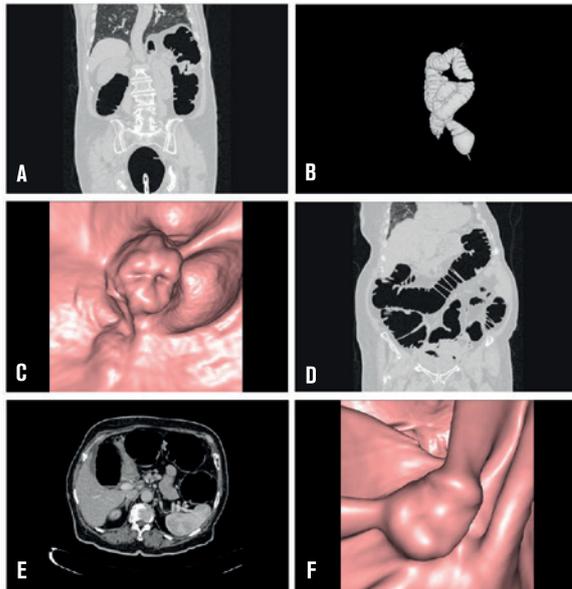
A 79 year-old female patient who had severe abdominal pain and constipation has undergone conventional colonoscopy but splenic flexure could not be passed because of obstructive tumor; coronal MPR (A), CT colonographic (B), 3D endoluminal (C) images demonstrating tumoral wall thickening at proximal descending colon leading to annular narrowing of the lumen; coronal MPR (D), axial (E), 3D endoluminal (F) images demonstrating broad-based synchronous polypoid lesion in dimension of 1x2 cm at distal transverse colon. The pathology report of the synchronous polypoid lesion demonstrated adenocarcinoma arising in base of tubulovillous adenoma.
